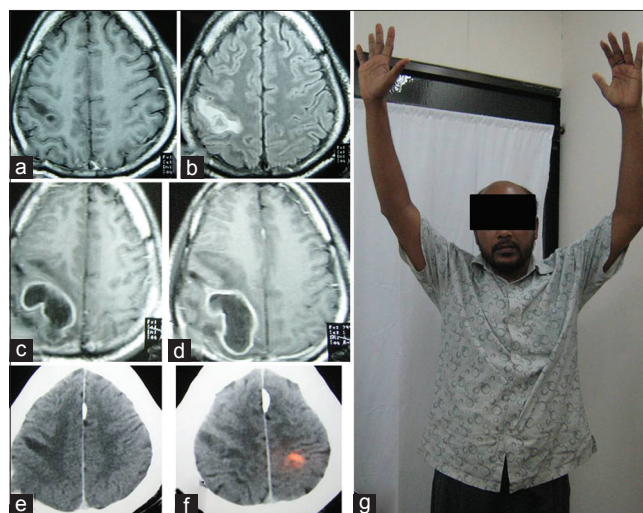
(a and b) MRI of brain axial sections, contrast and fluid-attenuated inversion recovery images respectively was done after sudden development of left sided hemiplegia showing noncontrast enhancing hypointense lesion in precentral gyrus; (c and d) contrast MRI of brain axial sections, 16 days after initial presentation showing ring enhancing lesion (abscess); (e and f) (contrast CT scan axial section 3 months after operation) showing resolution of abscess with some gliosis; (g) patient-3 months after operation (with full neurological recovery). CT: computed tomography; MRI: magnetic resonance imaging
